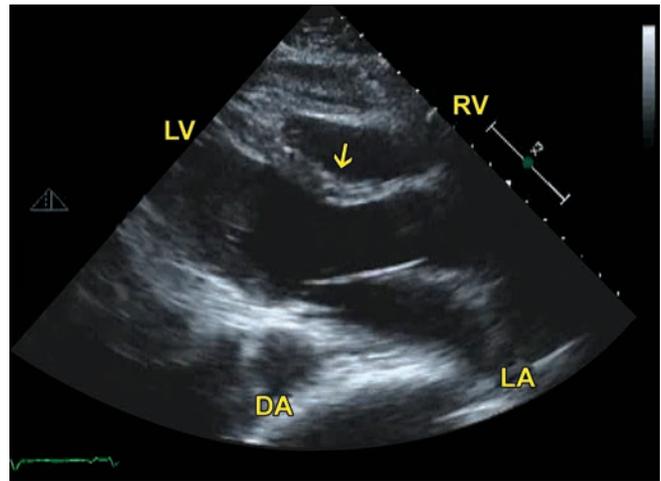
2D echocardiogram after pericardial effusion drainage. Arrow points to ventricular septum.
